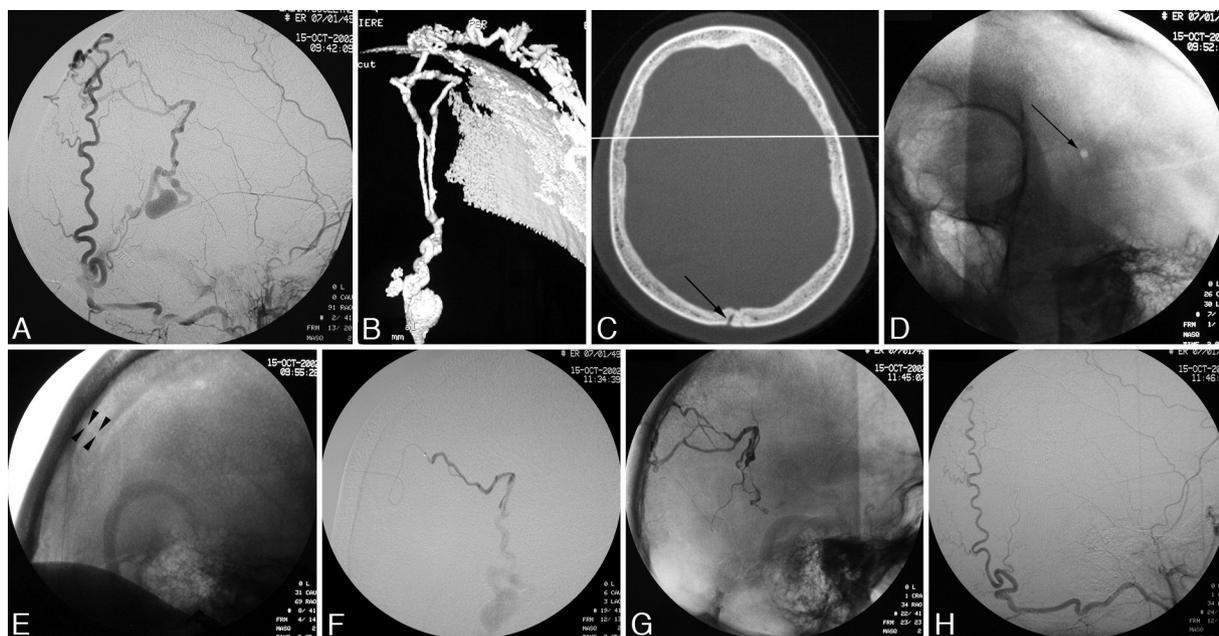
Case 1. Angiograms (A, B, and D–H) and CT scan (C). A: Lateral view of the right external carotid artery (ECA) showing a DAVF of the inferior edge of the falx cerebri, fed exclusively by the right OA. B: A 3D angiogram of the right ECA showing the transcranial course of the anastomotic vessel joining the OA to the intracranial feeding arteries of the fistula. C: A CT scan showing the course of the parietal foramen (arrow). D: Unsubtracted axial view of the parietal foramen showing the puncture site (arrow). E: Lateral view of the parietal foramen showing precise delineation of its lateral margins (arrowheads) as well as the inner and outer table of the skull. F: Image showing injection through the microcatheter after puncture of the parietal foramen and navigation with a microcatheter through the needle. G: View showing the cast of glue after embolization. The feeding arteries and the primary draining vein have been occluded. H: Image demonstrating the injection into the right ECA, confirming cure of the DAVF.
